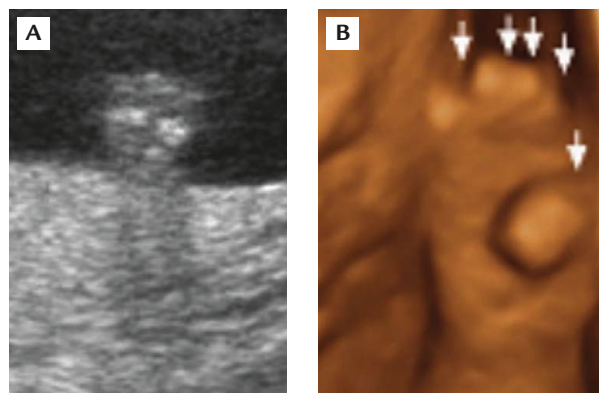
(A) Two-dimensional ultrasound demonstration of a clenched hand at 18 weeks of gestation. (B) Three-dimensional ultrasound demonstration of a mitten hand with a broad thumb and second-to-fourth-finger syndactyly (arrows) at 24 weeks of gestation.
